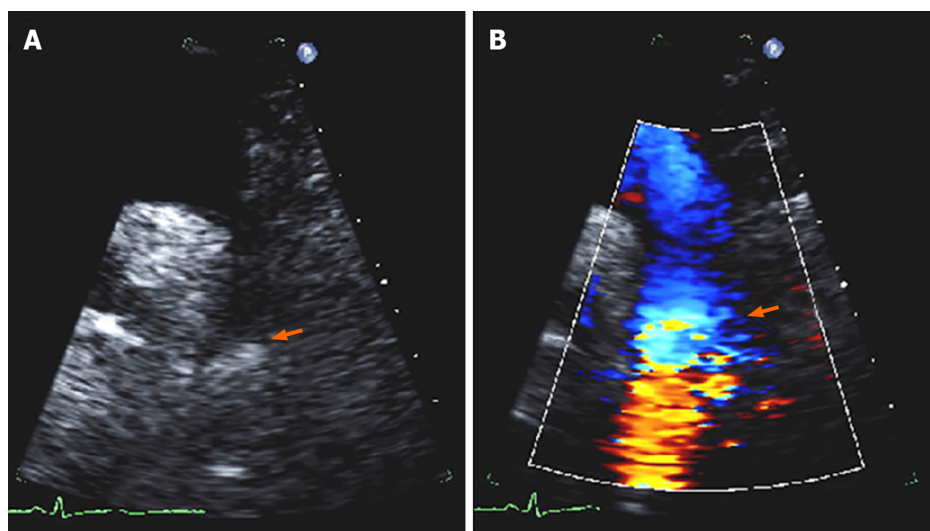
Echocardiographic findings in coarctation of aorta. A: Two-dimensional suprasternal view on transthoracic echocardiogram demonstrating narrowing in the aortic lumen at the isthmus (arrow); B: Color Doppler imaging demonstrating turbulent flow at the site of the coarctation (arrow).
